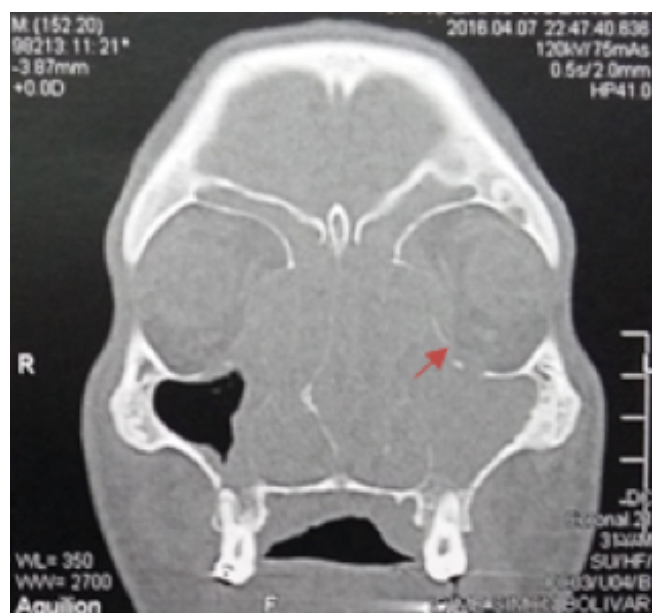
CT scan of nose and paranasal sinuses. Coronal view: complete occupation of left maxillary sinus, frontal and bilateral ethmoidal sinuses. Arrow: Eroded left lamina papyracea.
